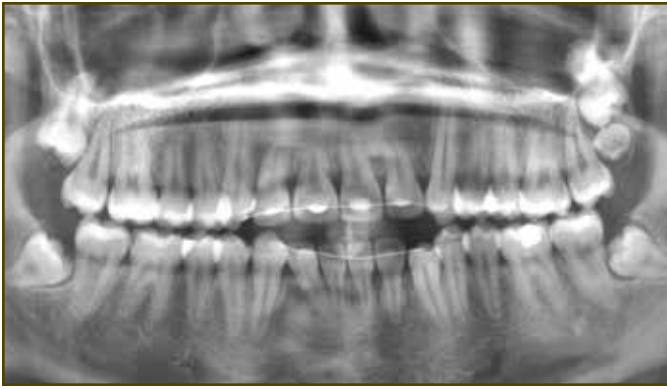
Panoramic x-ray. Note moderate root resorption of several anterior teeth, impacted third molars, and a supernumerary maxillary left third molar.
